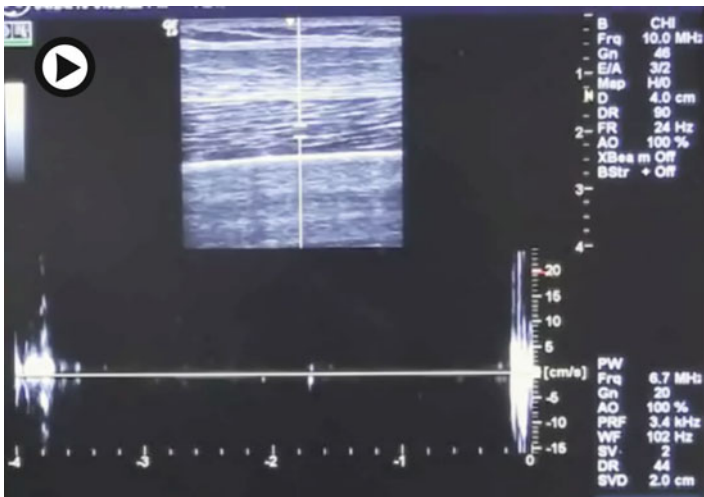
(Video 11.5) Stretch reflex with B mode (longitudinal view) and Doppler mode insonating the vastus intermedius (▶ <https://doi.org/10.1007/000-7qx>)
